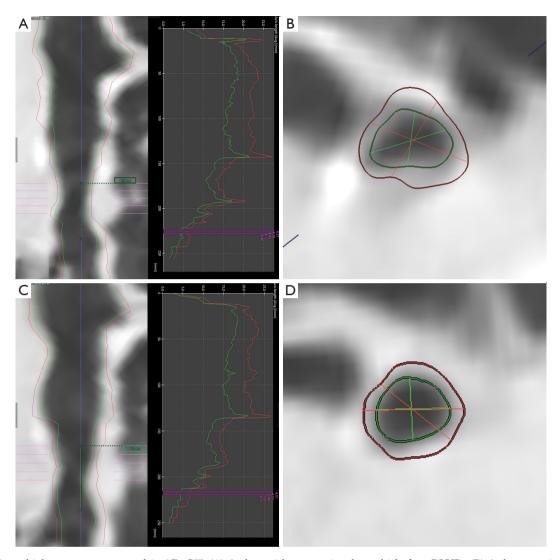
Bronchial structure measured in 3D-CT. (A) 2nd- to 4th-generation bronchi before BLVR; (B) 3rd-generation bronchial parameters before BLVR; (C) 2nd- to 4th-generation bronchi after BLVR; (D) 4th-generation bronchial parameters after BLVR. BLVR, bronchoscopic lung volume reduction.
